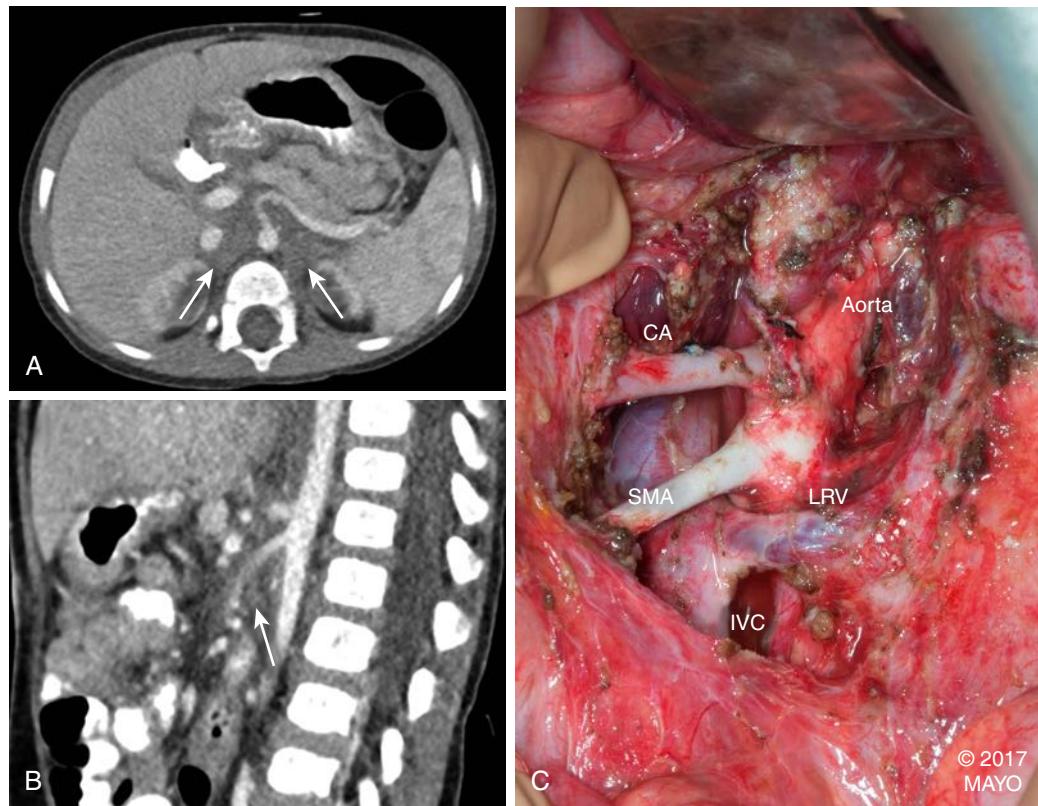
Infant with a neuroblastoma surrounding the paravisceral aorta, celiac, superior mesenteric, and left renal arteries and left renal vein, as shown by the arrows on axial and coronal CT images (A, B). The tumor could be separated from the aorta, branch arteries, and renal vein (C). CA, celiac artery; CT, computed tomography; IVC, inferior vena cava; LRV, left renal vein; SMA, superior mesenteric artery.
